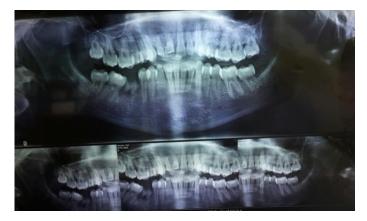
Preoperative orthopantomograph showing a single, large, mixed radiolucent-radiopaque lesion above11and 12 the apex area
